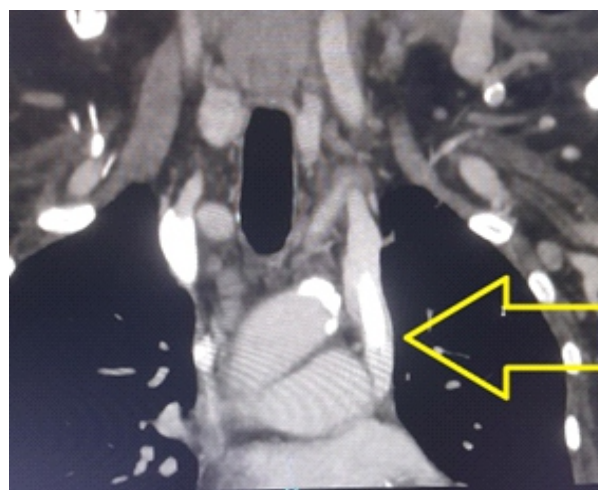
Computerised tomographic (CT) scan showing persistent left sided superior vena cava (PLSVC) and the dialysis access line (arrow) descending vertically downwards on the left side of the heart.
